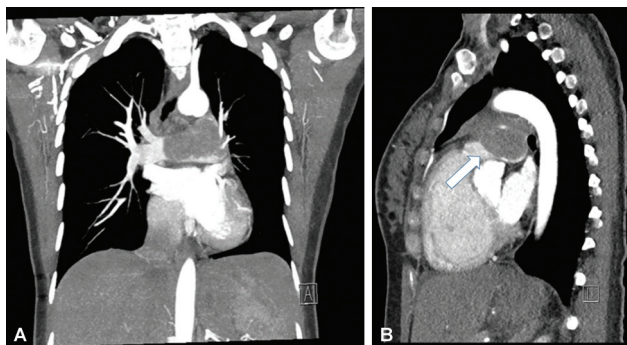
(A) Computed tomography (CT) angiograph revealing tumor mass. (B) Chest radiograph demonstrates prominent pulmonary artery segment on the left side and lysis catheter in the right pulmonary artery. Arrow indicates tumor mass in the pulmonary trunk.
